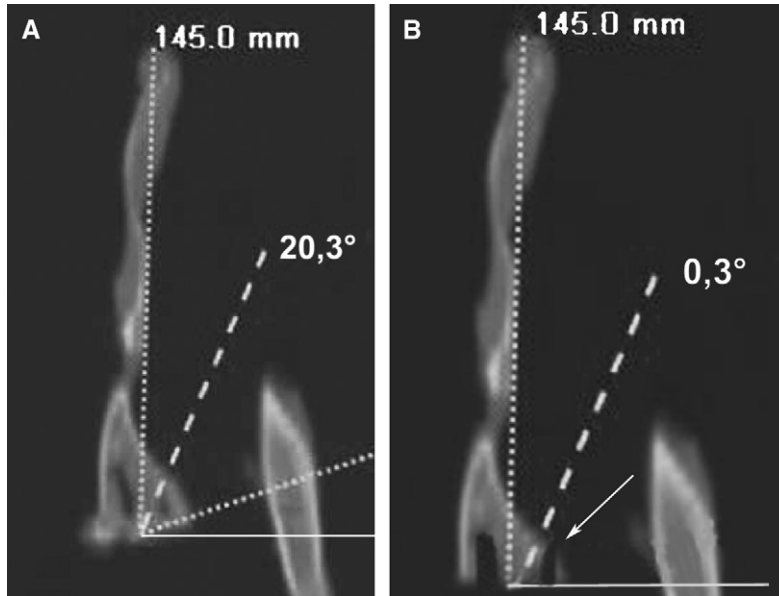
A, A computed tomography scan of the lesion shows a posterior retroversion of 20.3° (dotted lines: first between the anterior and posterior margins of the glenoid fossa and second, transverse axis of the scapula; plain line: perpendicular line to the transverse axis of the scapula). The break-off line shows the angle measured by the computer. B, A control computed tomography scan fracture of the posterior vault and image of polyethylene breakout (arrow).
